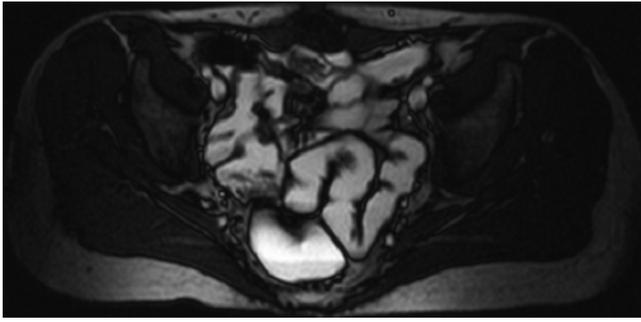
Magnetic resonance, axial T2-weighted fast spin-echo. Mean age female patient with recurrent abdominal pain. This image shows homogeneous small bowel loops distention and thin wall, thus negative for Crohn's disease.
